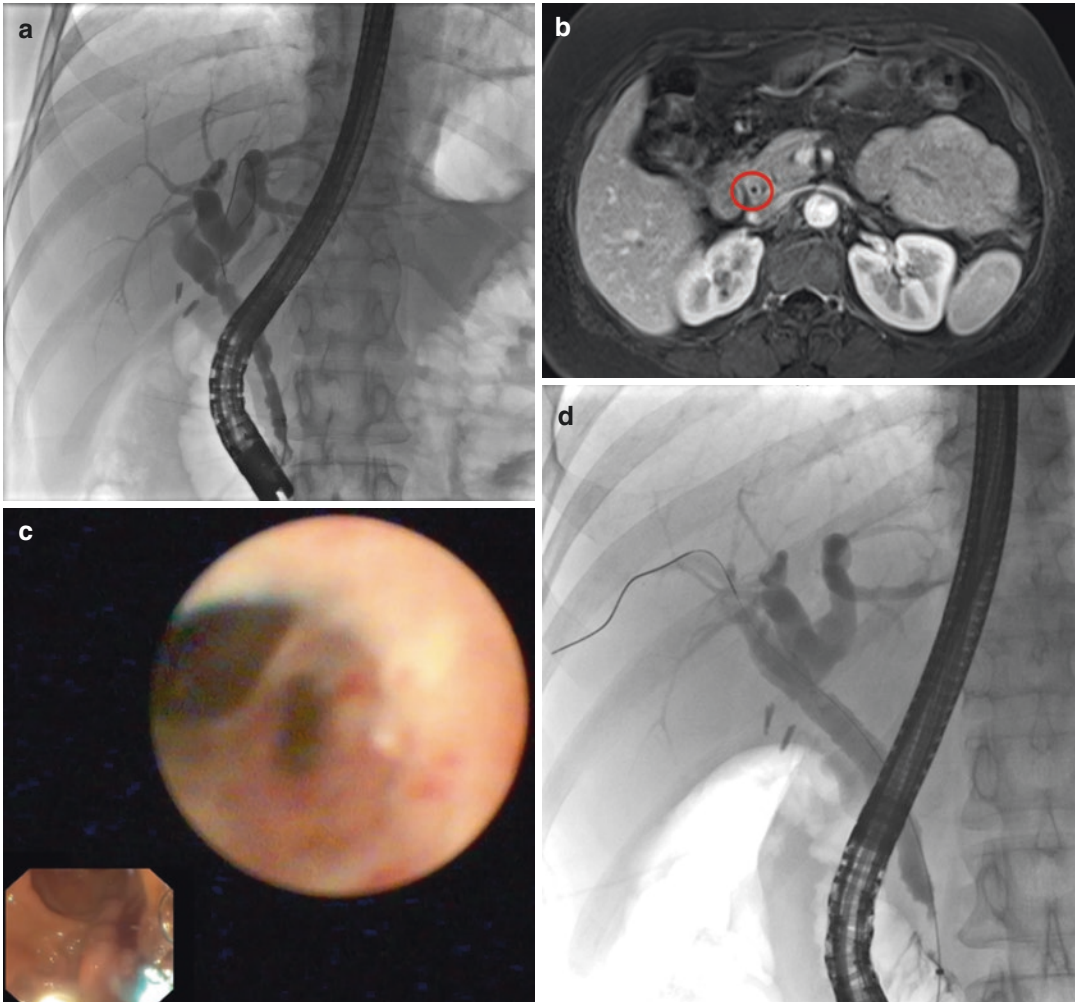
(a) 41-year old female patient with recurrent right upper quadrant pain for several years. Liver function tests showed a cholestatic pattern. ERCP indicates irregular narrowing all of the complete CBD and the hepatic hilum, with clips dating from a previous cholecystectomy. (b) At MRI, the common bile duct (CBD) shows thickening of the wall with increased uptake of contrast. (c) At cholangioscopy, diffuse sclerosing lesions of the CBD
